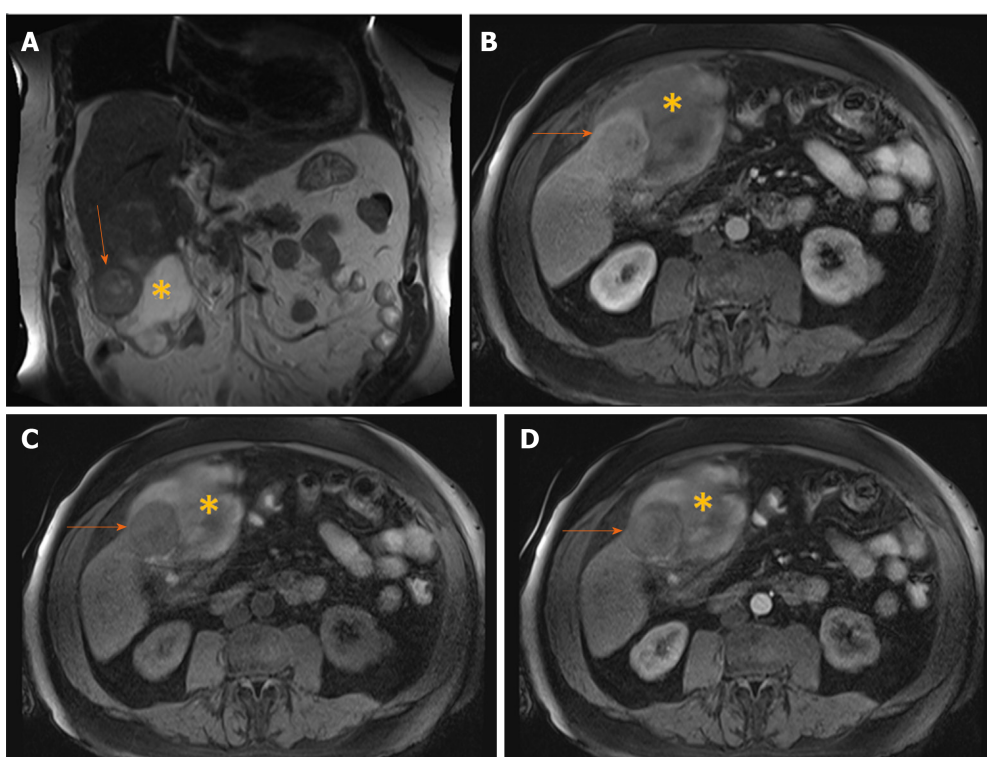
Hemorrhagic hepatocellular carcinoma in 70-year old man with cirrhosis presenting with acute abdominal pain. A: Coronal T2-weighted image shows a nodular tumor (arrows) in the subcapsular location in segment V, and subhepatic hematoma (asterisk); B: Axial T1-weighted FS image shows hypointense tumor (arrows) and hyperintense content of the hematoma (asterisk); C and D: Arterial phase displays only subtle hypervascularity in the part of the tumor (arrows) depicted on this section (C) with washout in portal venous phase (D), and hematoma (asterisk) located anteriorly.
